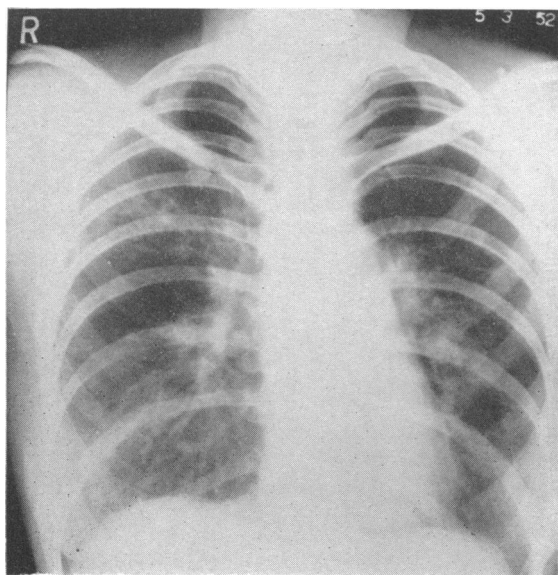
Case 4. Radiograph of chest, March, 1952.
